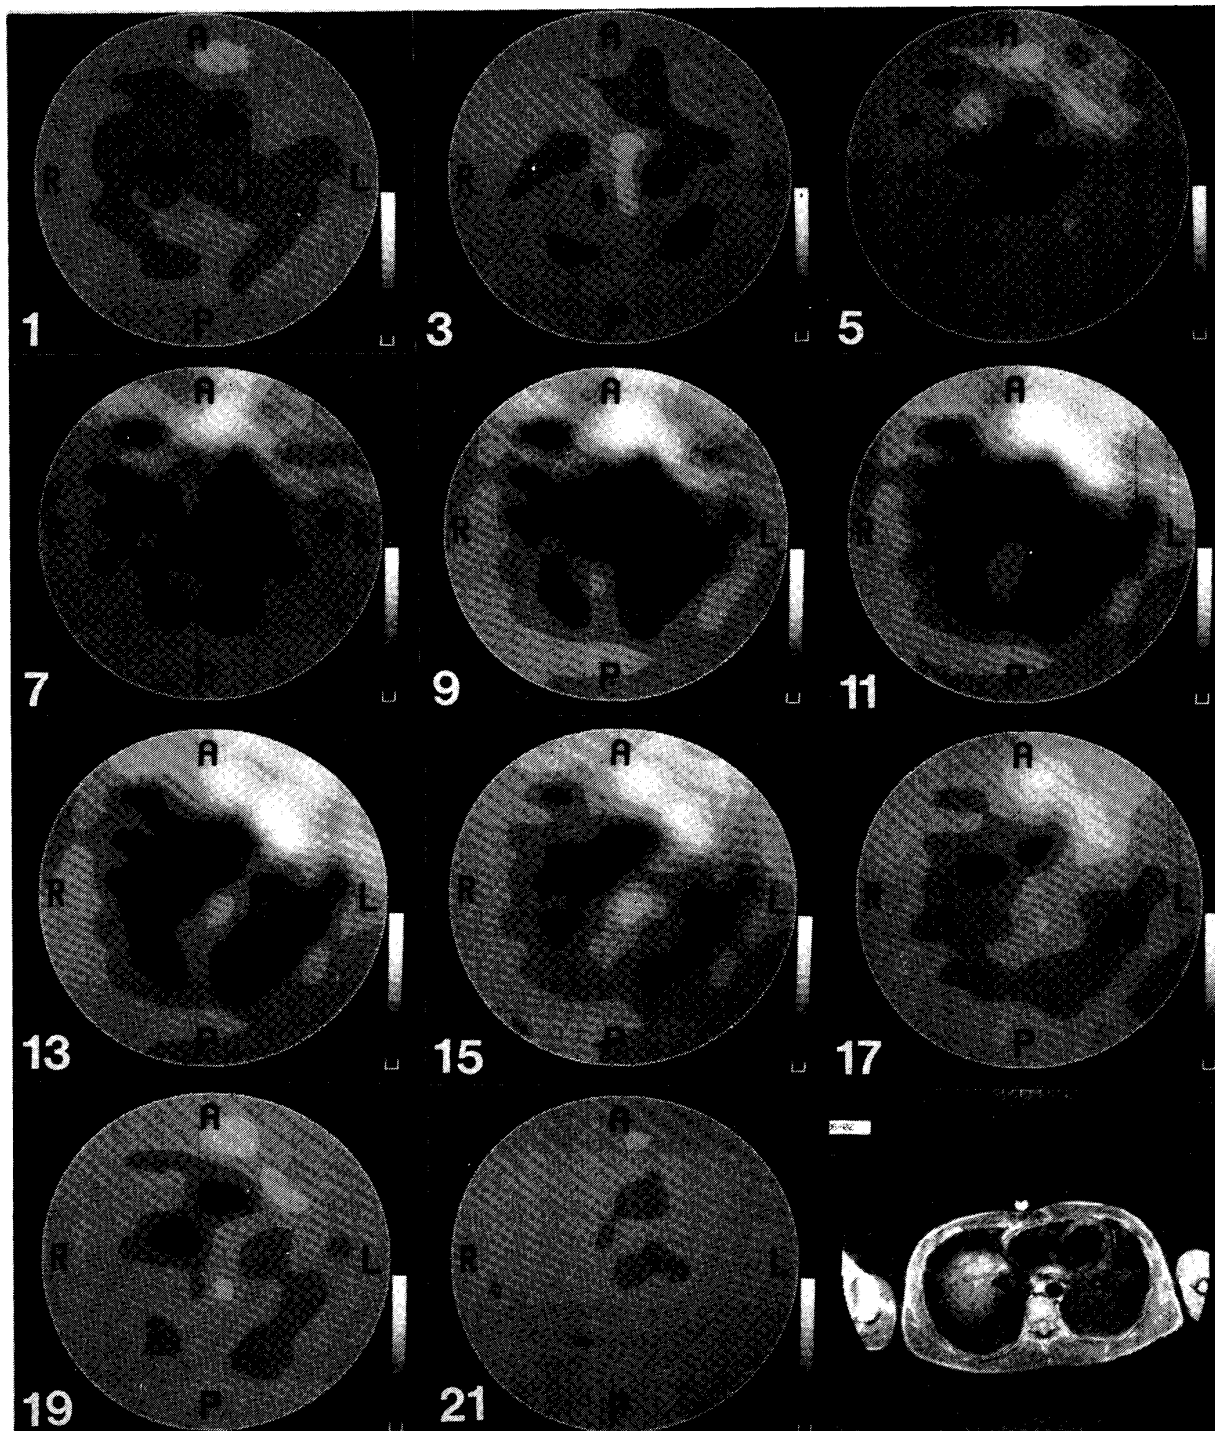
A sequence of EIT images collected at 42 ms intervals during the cardiac cycle. Only odd-numbered frames are given. Images are reconstructed with the reference at end-diastole (frame 4), therefore, all other frames represent the changes in resistivity relative to frame 4. Resistivity of blood is relatively lower than most of the other tissues. Therefore, regions where blood accumulates during systole appear as decreased resistivity (dark) and the regions where blood is removed appear as increased resistivity (bright) in the images. Frames 1 to 3 are towards end-diastole; as all regions approach their reference values (frame 4), the resistivity changes are very small. At frame 4, end-diastole, the ventricles are filled with blood and their resistivity is at its minimum, whereas the resistivity of aorta and lungs is at a maximum. The *R*-wave occurs at frame 5. Following ventricular contraction, the average resistivity of the ventricles starts increasing. During systole, frames 5 to 11, the increase in the resistivity of the ventricles is accompanied by a decrease in the resistivity of the aorta and major arteries due to radial dilatation and the lungs due to perfusion with blood. Frames 12 to 21 belong to diastole; with the return of blood to the ventricles, their resistivity reaches a minimum value and aorta and lungs their maximum values (i.e., to their reference values and hence disappear in the image). Frames 1 and 20 represent approximately the same time in the cardiac cycle. The MRI scan of the same subject, 210 ms after the *R*-wave, is given for comparison in the bottom right corner. Orientation of the MRI image is the same as that of EIT. In the EIT images, the letters P, A, L, and R show posterior, anterior, left and right, respectively.
